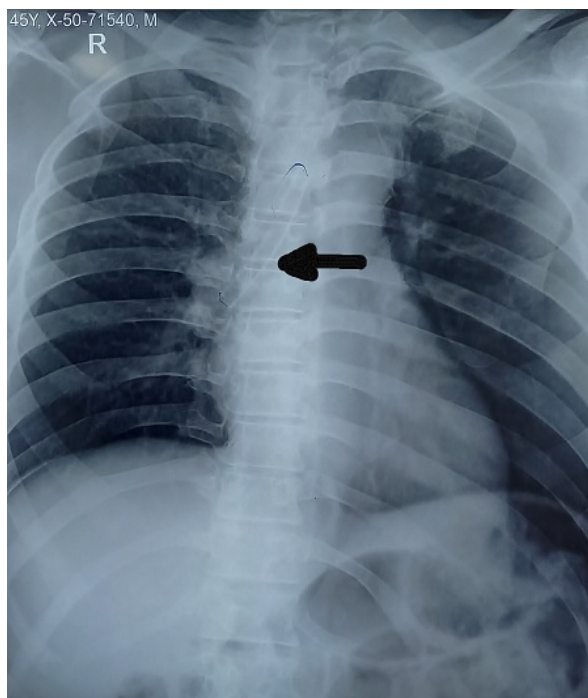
Chest X-ray PA view showing broken tracheostomy tube in the right main bronchus and distal trachea.
